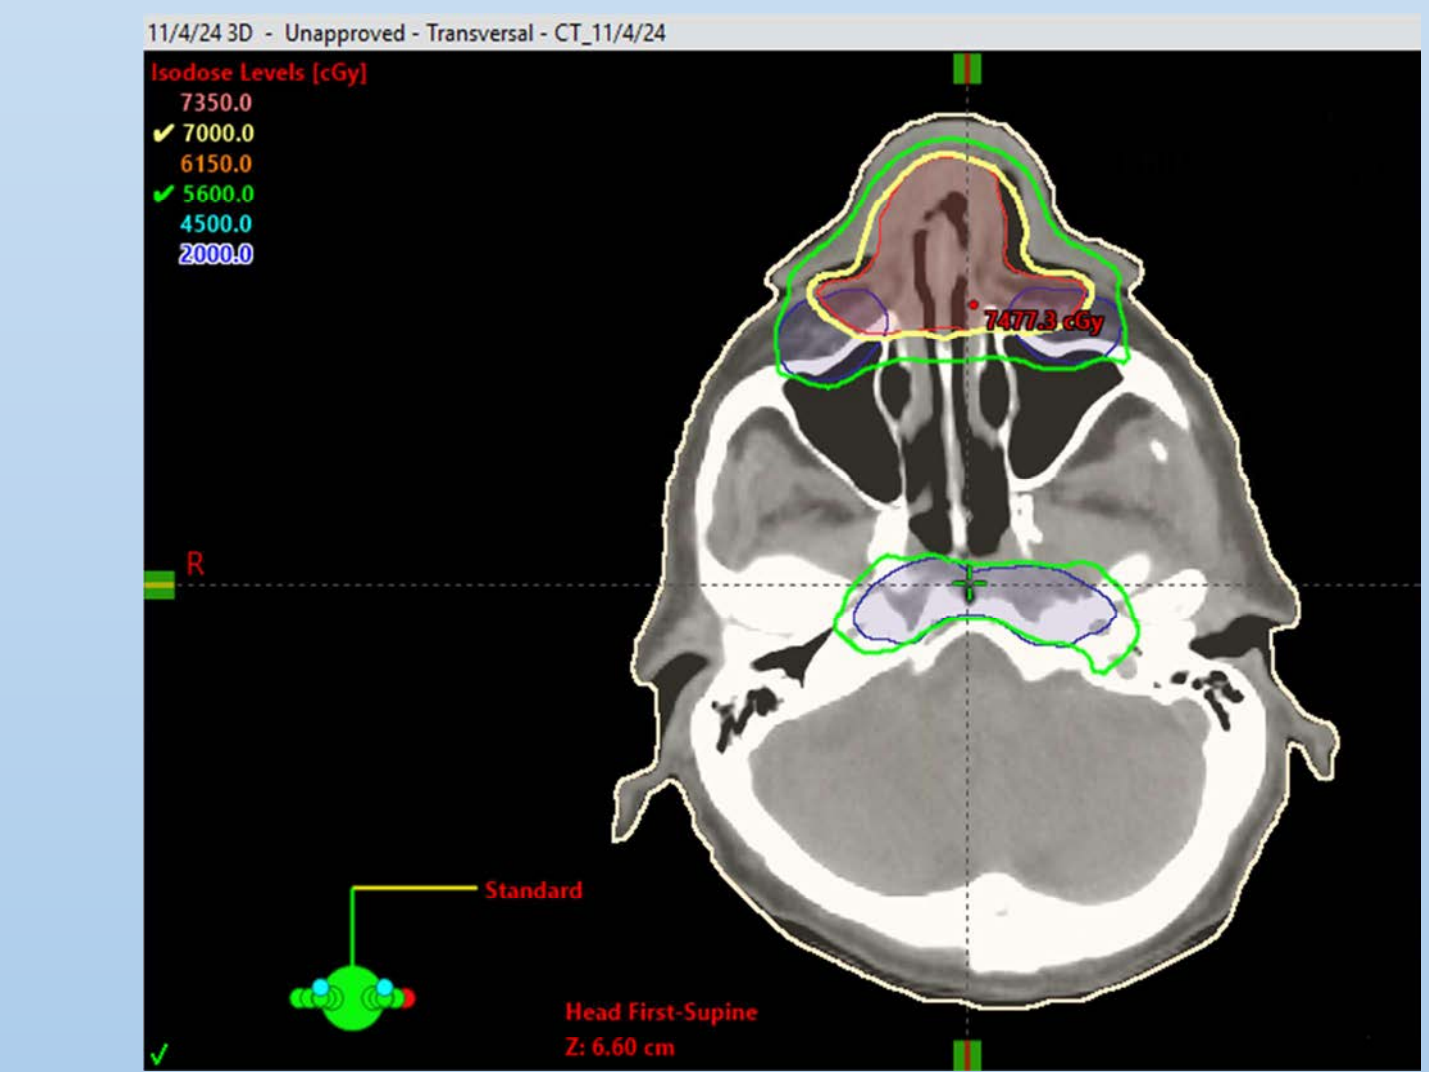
Calculated plan on CT with 3D printed bolus
